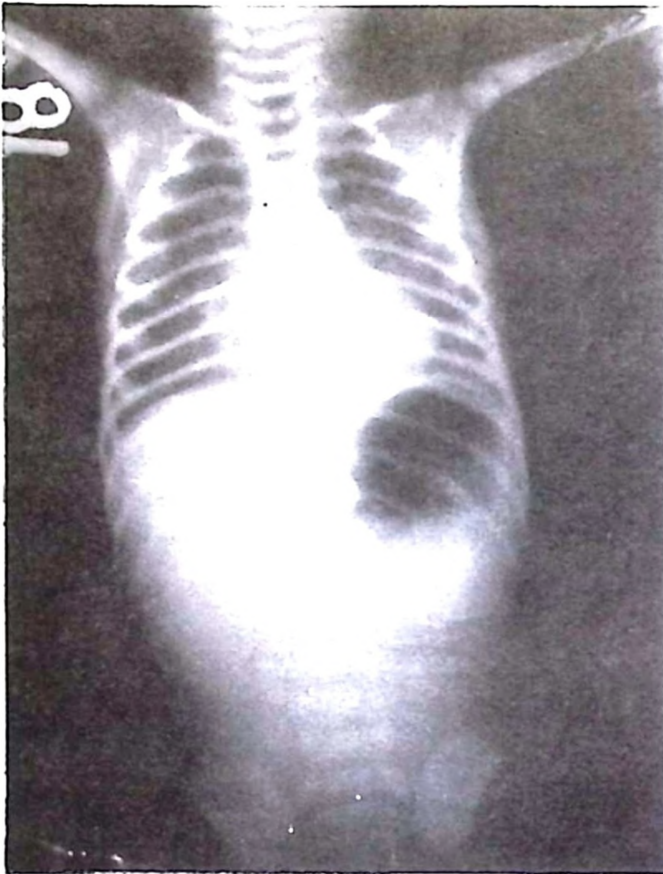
Abdominal x-ray of the infant.
